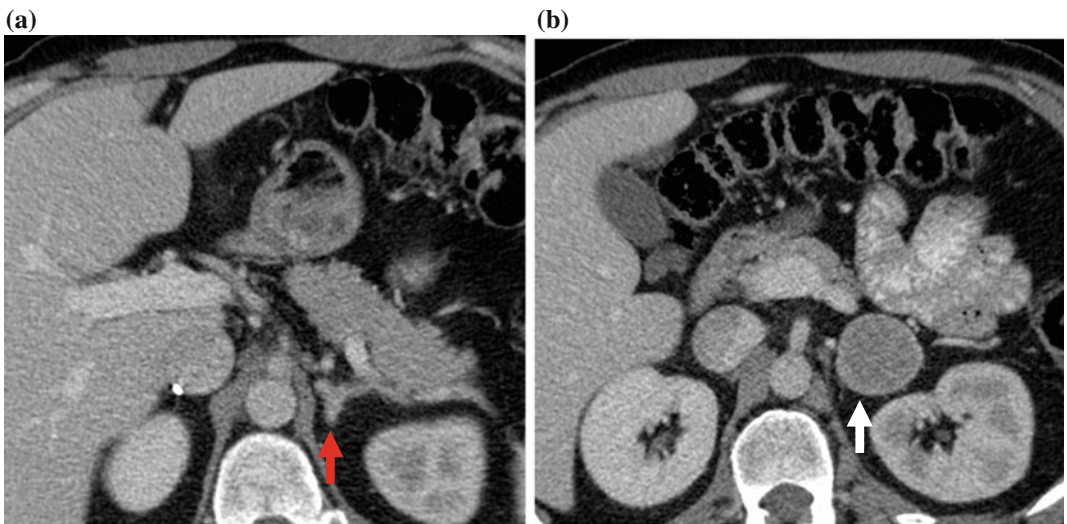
Axial CT image of a left adrenal gland in an MEN2A patient who had undergone prior right complete adrenalectomy in the past and was referred for cortical-sparing left adrenalectomy. a Normal appearing adrenal limb at the superior extent of the left-sided pheochromocytoma (*red arrow*); b Pheochromocytoma (*white arrow*)
